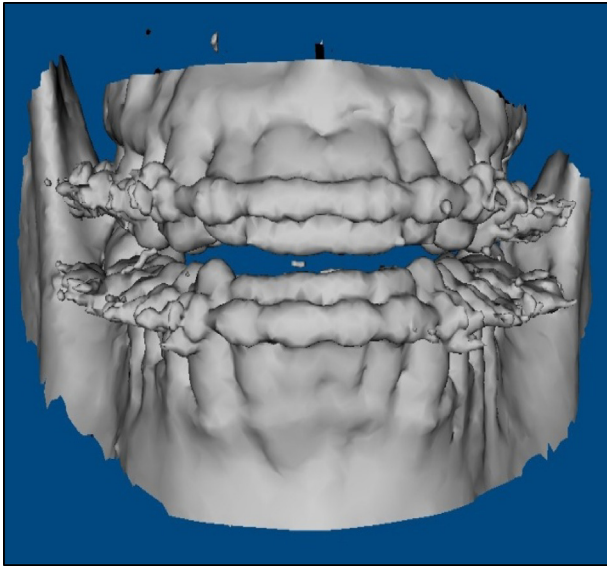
3D CBCT of the mandible showing the streak artefacts of the associated teeth.
